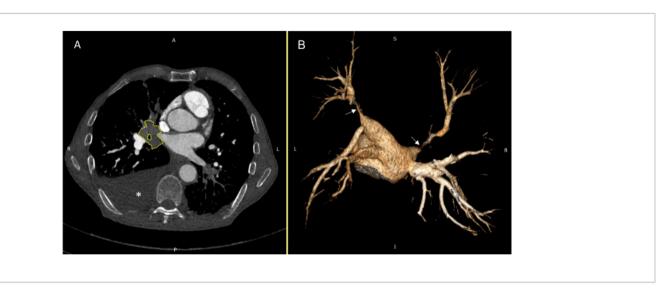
CTPA of the mediastinal window. The CTPA image of the mediastinal window on admission shows hyperplastic soft tissue (dotted line in A) compressing the pulmonary vessels, resulting in pulmonary vein stenosis (PVS) (arrow in B). The asterisk in A indicates pleural effusion.CTPA: computed tomography pulmonary angiography; PVS: pulmonary vein stenosis. Please click here to view a larger version of this figure.
